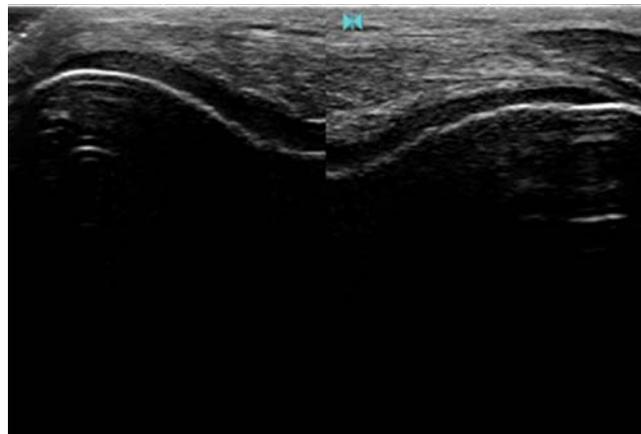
An ultrasound scan showing an articular cartilage layer covering the femoral condyle
